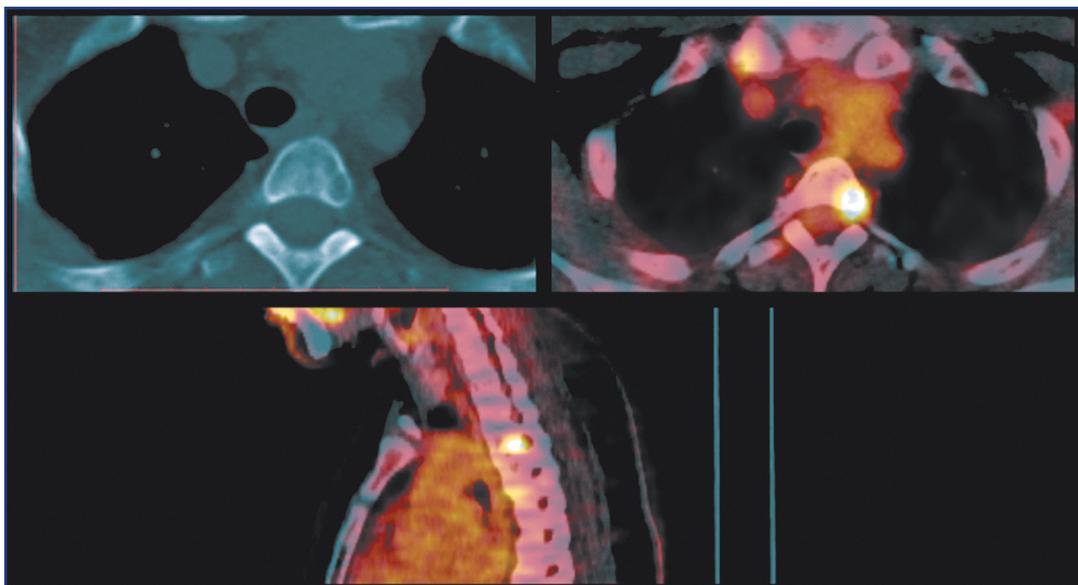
PET/CT. Metastasis to the arch Th4 root on the left.
